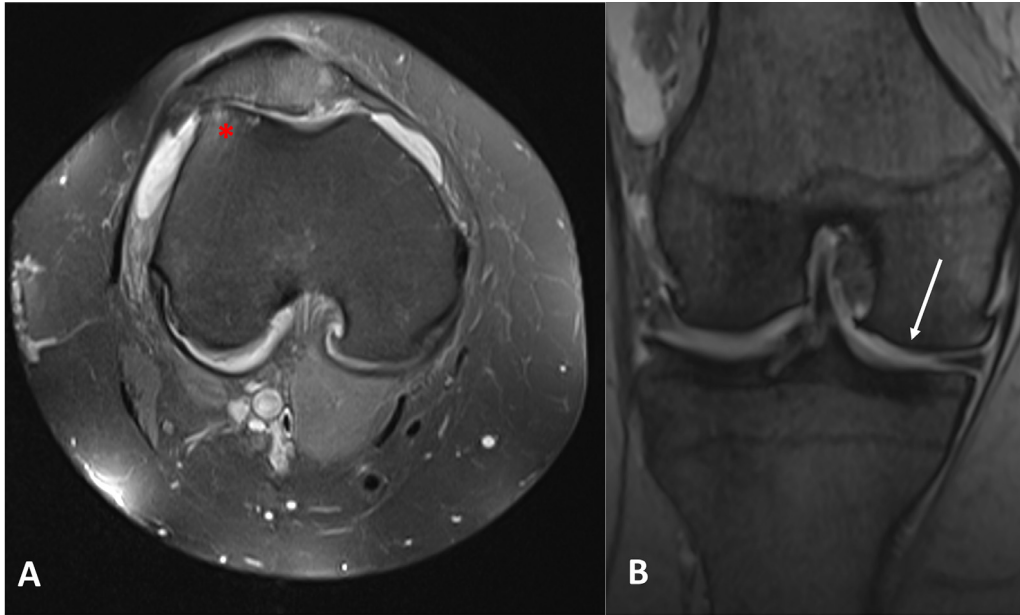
Axial PD fluid sensitive (A) and coronal T2 (B) MRI sequences. There is severe patellofemoral arthropathy with marked loss of joint space, full thickness loss of articular cartilage, cortical irregularity and underlying cystic change with marrow oedema signal (asterisk). There is mild loss of medial compartment joint space and attenuation of articular cartilage (arrow).
